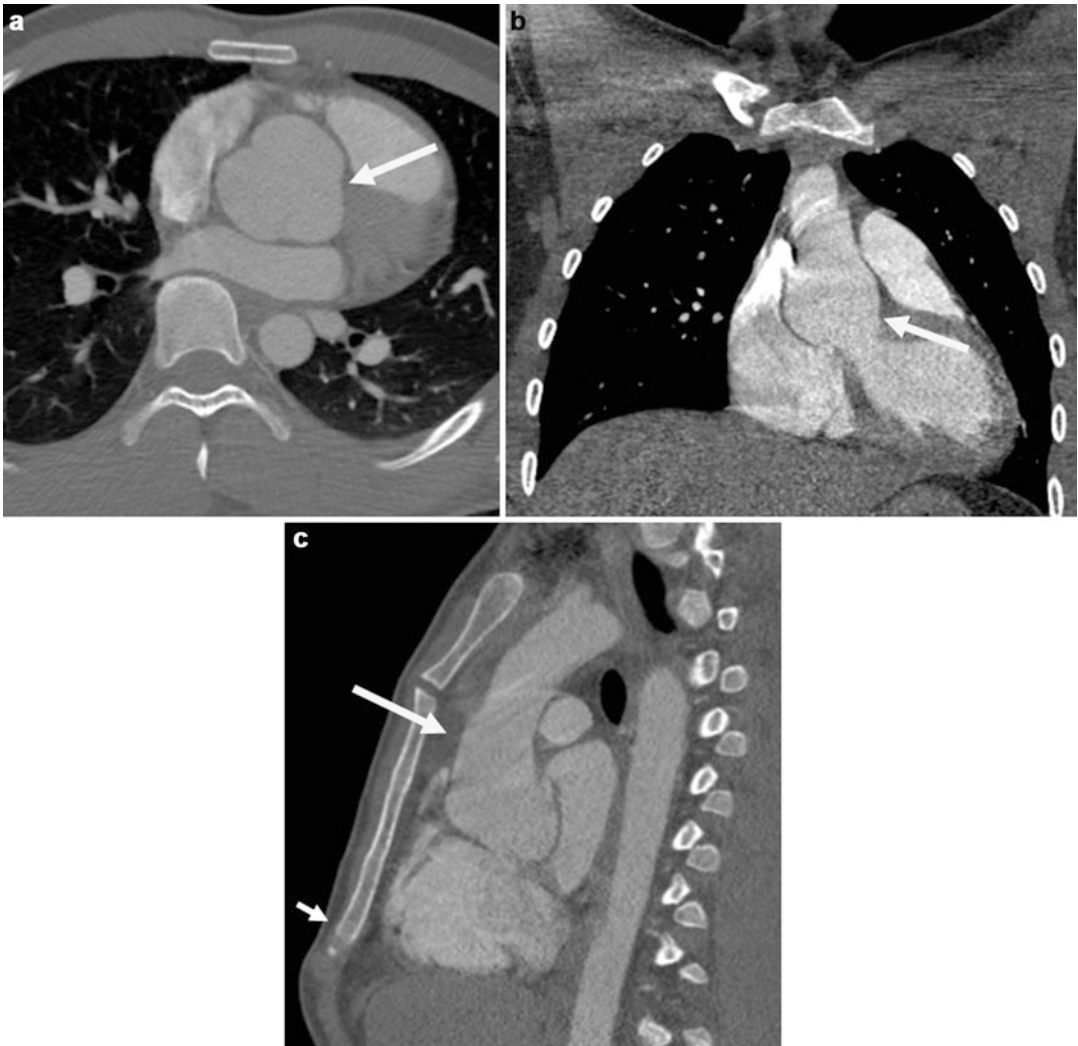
(a–c) A 17-year-old male was evaluated because of a history of Marfan syndrome with complaints of headache and tearing back pain. He was noted to have pectus carinatum since birth. Since 12 years of age, he was noted to have flat feet and hyperextensible joints. He wore glasses and was told that he did not have lens dislocation (no ophthalmologic record was available). Previous echocardiogram (not shown) confirmed a markedly dilated aortic root of 3.8 cm (a Z-score of approximately +5.5). There was clover-leafing, also suggesting dilated aortic root. There was mild ascending aorta dilation and trivial mitral valve prolapse. Chest radiographs (not shown) showed a good expansion of left aortic arch and a
